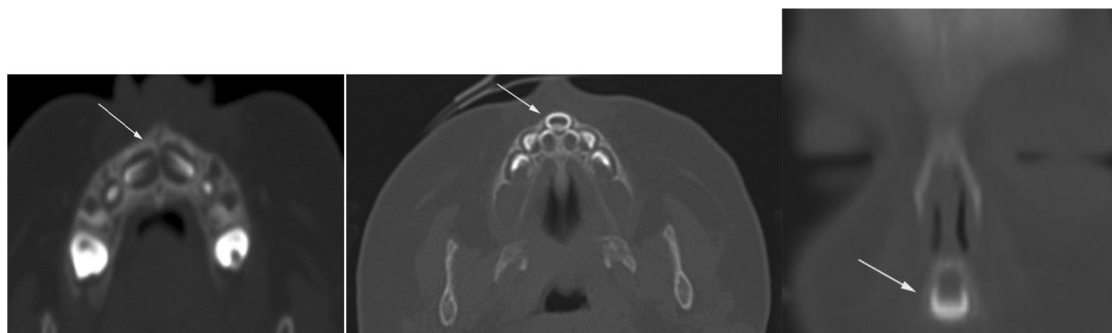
CT images through the hard palate in two 9-month-old females. An axial view of maxillary segment with normal tooth crowns is shown on the far left (arrow). In contrast with an axial view showing a solitary median maxillary central incisor (middle image, arrow). On the far right is a coronal view of a solitary median maxillary central incisor (arrow).
